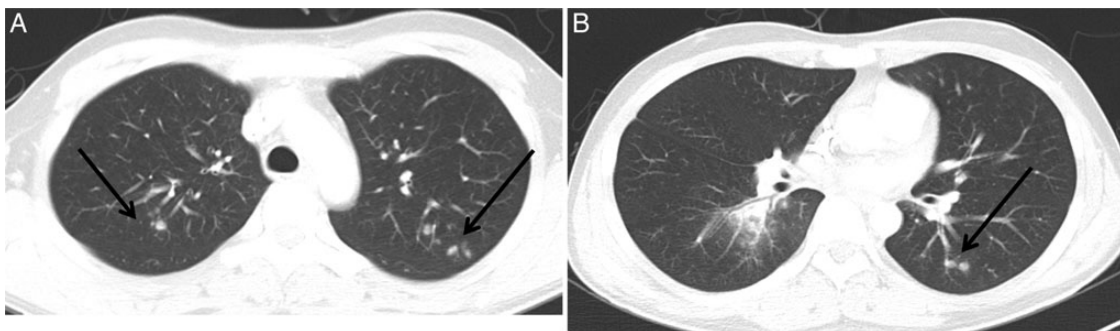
Computed tomography (CT) images obtained in a 29-year-old man with airway-invasive pulmonary aspergillosis who underwent a hematopoietic stem cell transplant 2 months previously. *A* and *B*, Conventional CT lung images (5-mm thick) obtained at the level of the aortic arch and right lower lobar bronchus. The images show ill-defined centrilobular nodules in both upper lobes and left lower lobe (arrows). Note diffuse and smooth thickening of lobar and segmental bronchi of right lower lobe and surrounding halo sign of peribronchial consolidation in right lower lobe.
